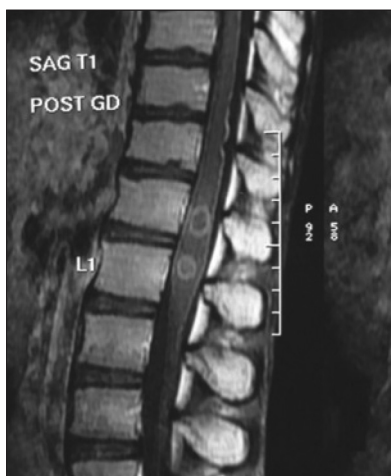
Post-Gadolinium magnetic resonance imaging image of dorso-lumbar spine revealing two ring enhancing lesion (target sign) at D12 and L1 level suggestive of tuberculoma
